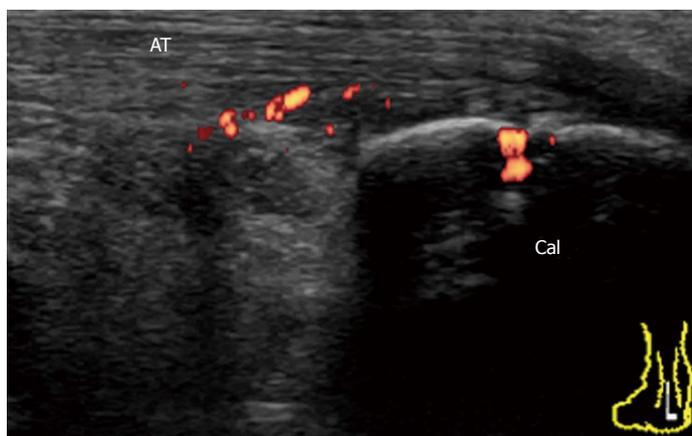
Achilles tendon enthesitis in early undifferentiated spondyloarthritis. Longitudinal power Doppler sonogram of the AT shows abnormal vascularization at the enthesis insertion into the calcaneal bone with minimal tendinosis. Cal: Calcaneus; AT: Achilles tendon.
